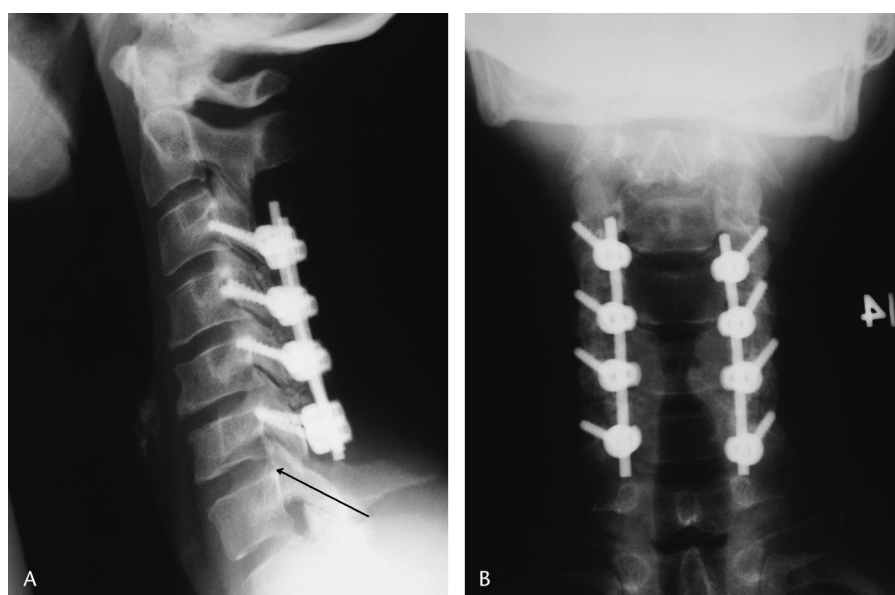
Anteroposterior (A) and lateral (B) postoperative C-spine radiographs of a typical patient who underwent C3–C6 lateral mass fixation, the most common construct used for spondylotic myelopathy. The position of the screws is well demonstrated; in the lateral radiograph, the steeper trajectory required to cannulate the relatively shallow C7 lateral mass is arrowed.
